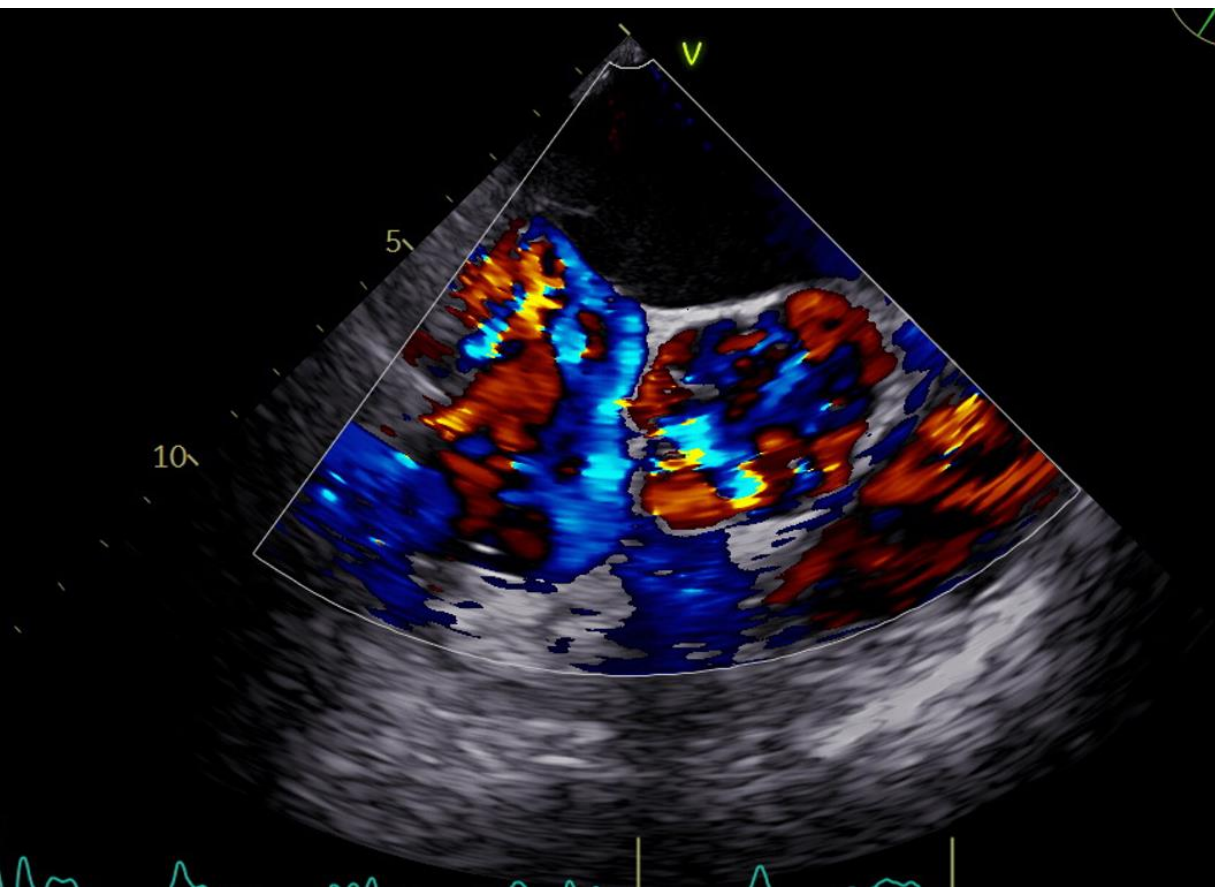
Valve perforation as seen on TEE with doppler
